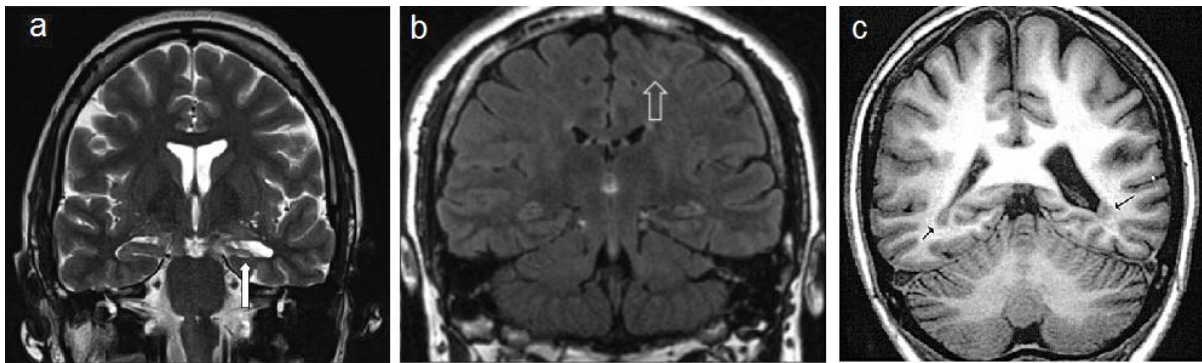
Coronal MR images show a decrease in the volume of the left hippocampus in a case of TLE (a), a focal cortical dysplasia of the left superior frontal sulcus in a case of frontal lobe epilepsy (b) and bioccipital periventricular heterotopia in a case of occipital lobe epilepsy. Adapted with permission of Wolters Kluwer Medknow Publications and Oxford University Press from (Singh et al., 2013; Taylor et al., 2003; Winston et al., 2013).
